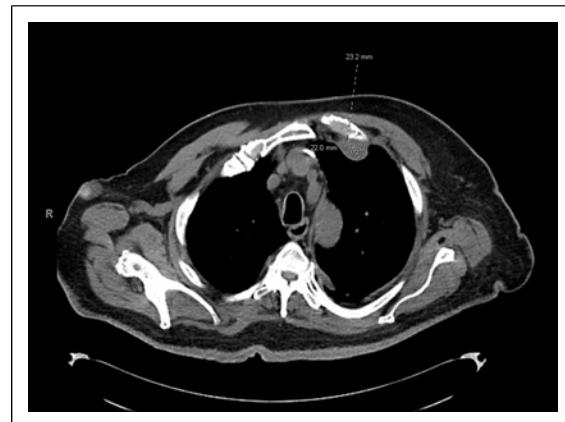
Axial CT chest showing mediastinal mass measuring 22.0 by 23.2 mm, adjacent to mammary lymph nodes.
